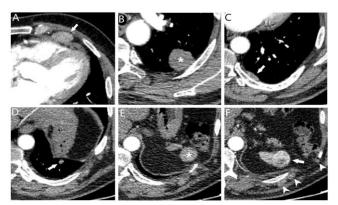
In axial CT, sections passing through the thorax, a mass formation at the left anterior diaphragmatic level (arrow) (a), a mass lesion in the apicoposterior segment of the left upper lobe (asterisk) (b), pleural plaque-like soft tissue in the lower lobe of the left lung (arrow) (c), and a subpleural nodule in the same lobe (arrow) (d). In axial CT sections passing through the upper abdomen, there is ovoid soft tissue (asterisk) in the spleen lodge (e), a defect in the abdominal wall, ovoid
